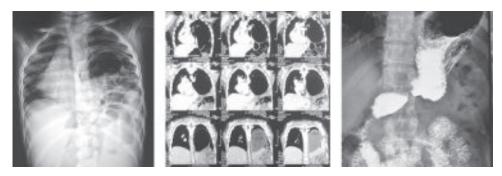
2&3: Left sided Diaphragmatic eventration evident by X-Ray Chest P/A view, CT Scan of Chest and Contrast X-Ray of Stomach.
